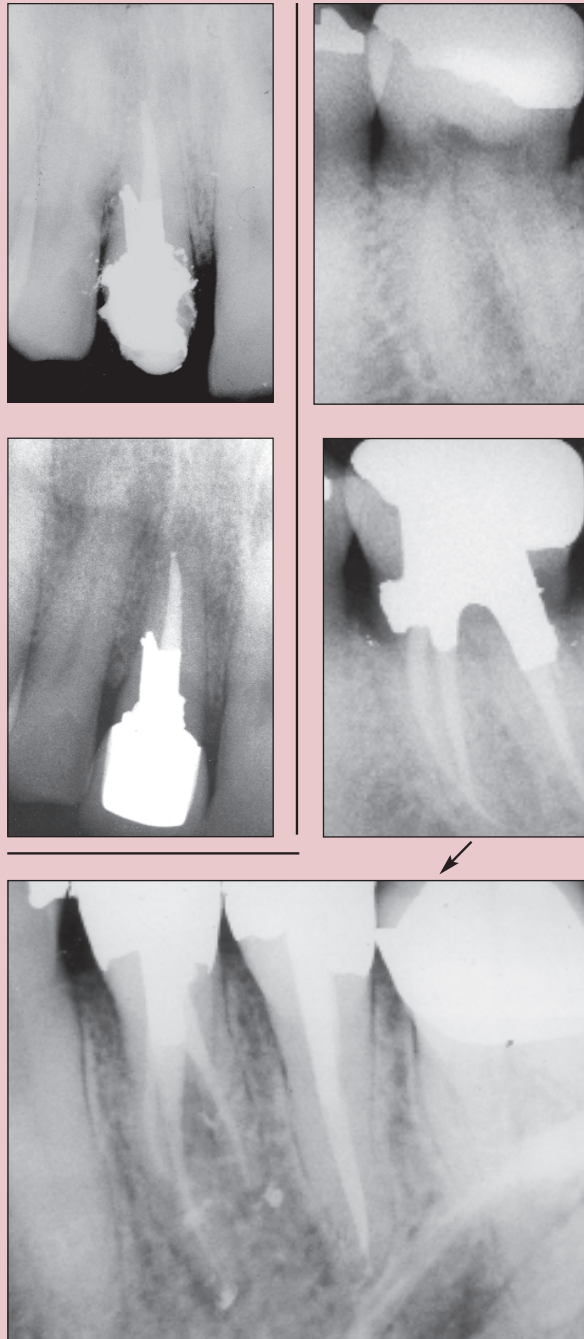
Radiographs of an upper anterior tooth with a perforation defect in the upper portion of the chamber. Post placement with cast metal would be predisposed to failure whereas amalgam serves as a seal for the perforation and as a post-endodontic restoration. A lower molar with a significant resorptive defect at the level of the CEJ. The amalgam post core provides adequate coronal restoration and seals the area of restoration simultaneously. An upper first bicuspid with three roots which are severely dilacerated unamenable to cast metal post placement. The well adapted amalgam post core restoration seals the chambers three-dimensionally eliminating the possibility of coronal and cervical leakage and providing adequate resistance to coronal fracture
